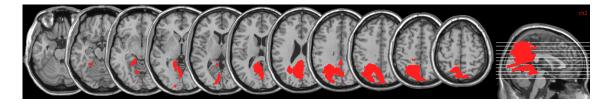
CT images for patient ME overlaid on a standard brain.
